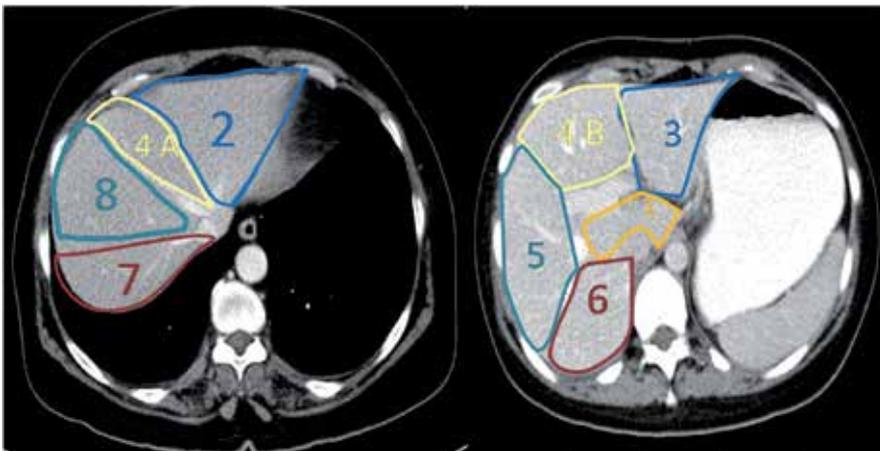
All segments identified on CT pre-opretive
